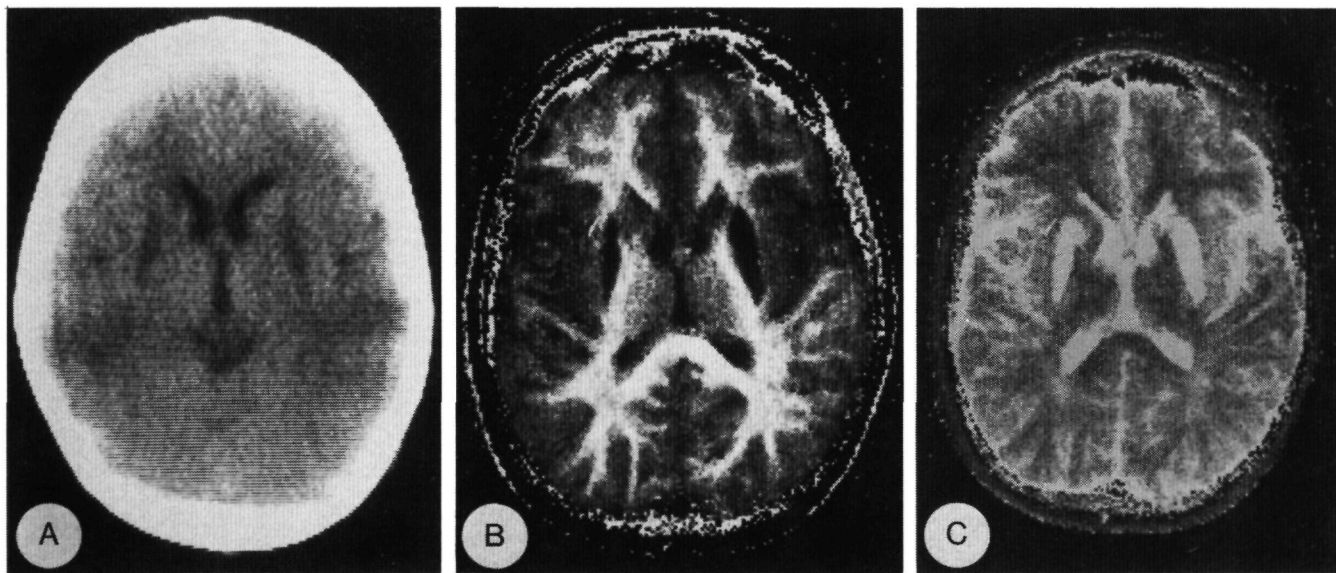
(Case 1). A, CT image. Hypodense areas in the putaminal regions. B, calculated T₁ image. Hypointensive areas in the putaminal regions and head of the right caudate nucleus. C, calculated T₂ image. Hyperintensive areas in the putaminal regions and head of the right caudate nucleus.
